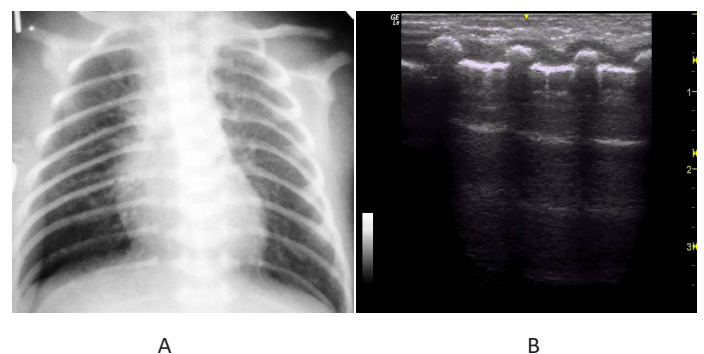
Newborn, gestational age 33 weeks. Respiratory distress syndrome of I degree. A. X-ray reveals the deformation of the pulmonary pattern according to the reticular-granular type. B. An ultrasound reveals single B-lines (arrows).
